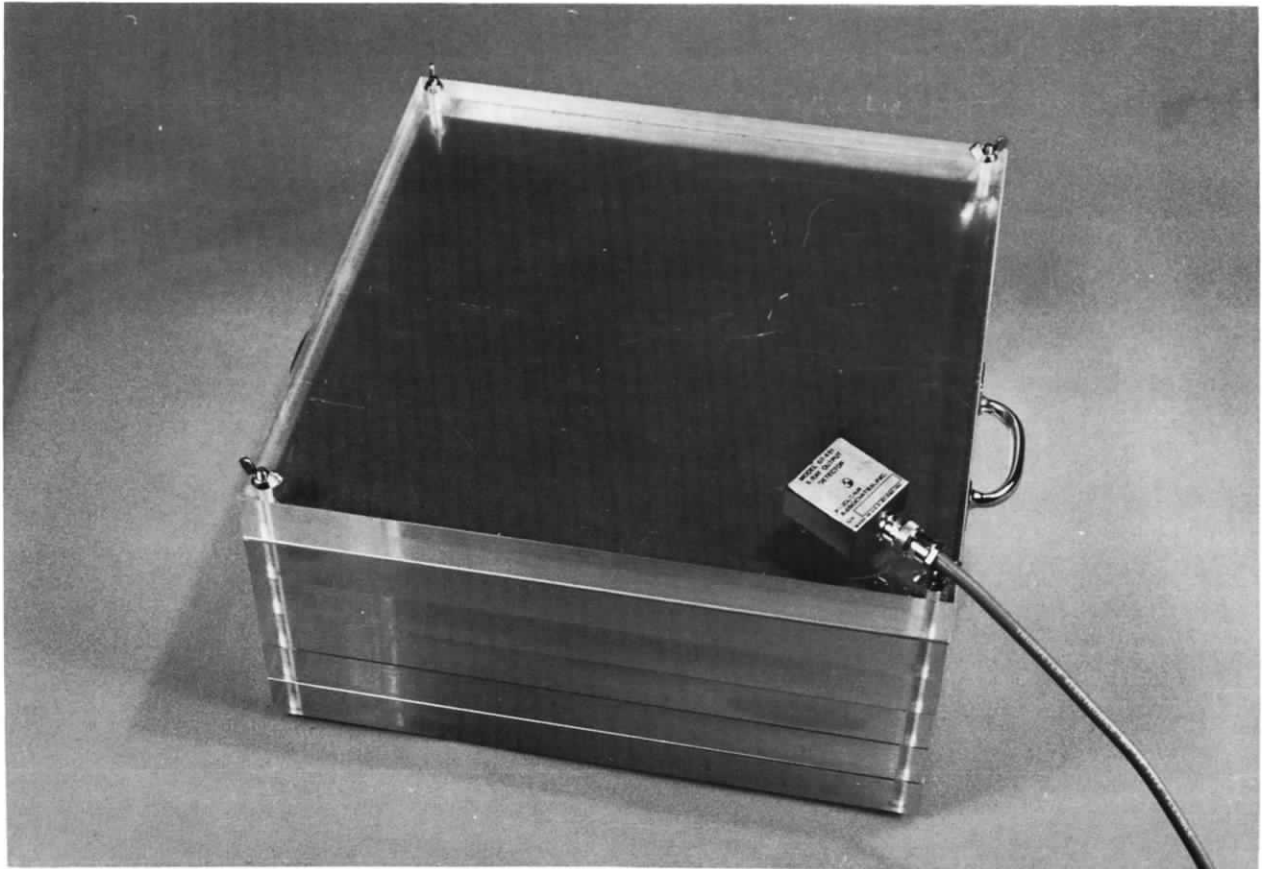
The detector should be placed about 50 cm from the x-ray source to avoid saturation of the detector. We place the detector on top of the PEP and monitor waveforms during all exposures made with the PEP.
